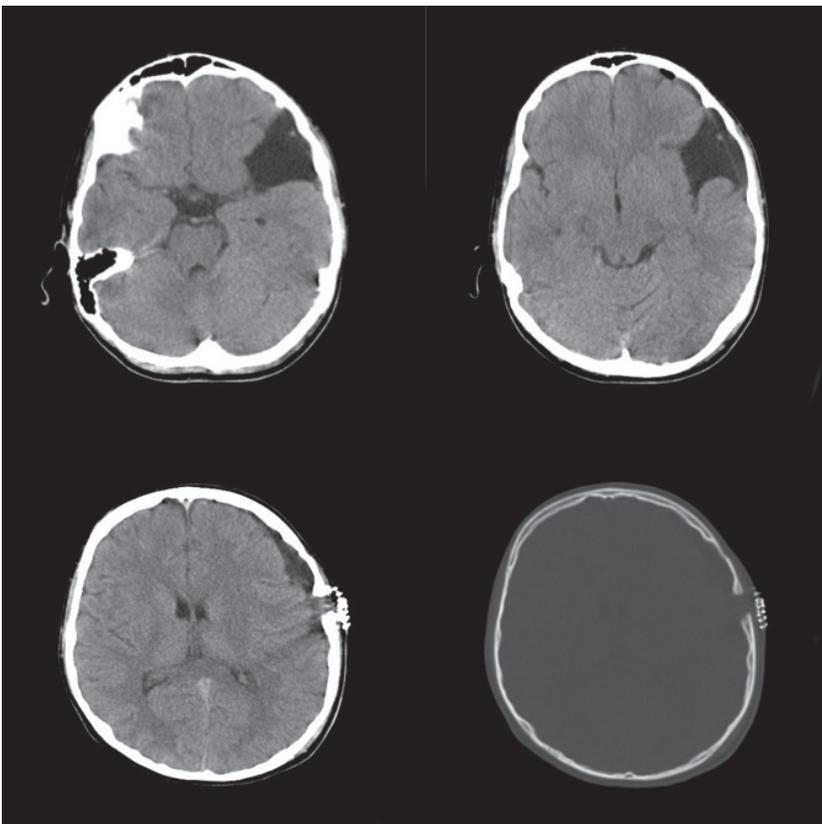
Postoperative CT scan images of the existing left temporal Sylvian arachnoid cyst with the resolution of the subacute subdural haematoma and the intracystic haematoma.
